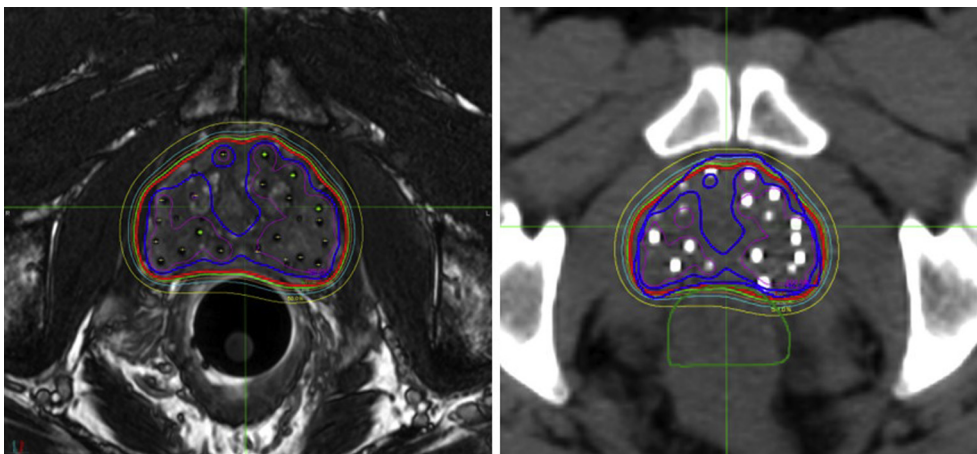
CT and MR images for dosimetric assessment after implantation of seeds. The anatomic boundaries are notably clearer on the MR images (left) compared with CT images (right).
